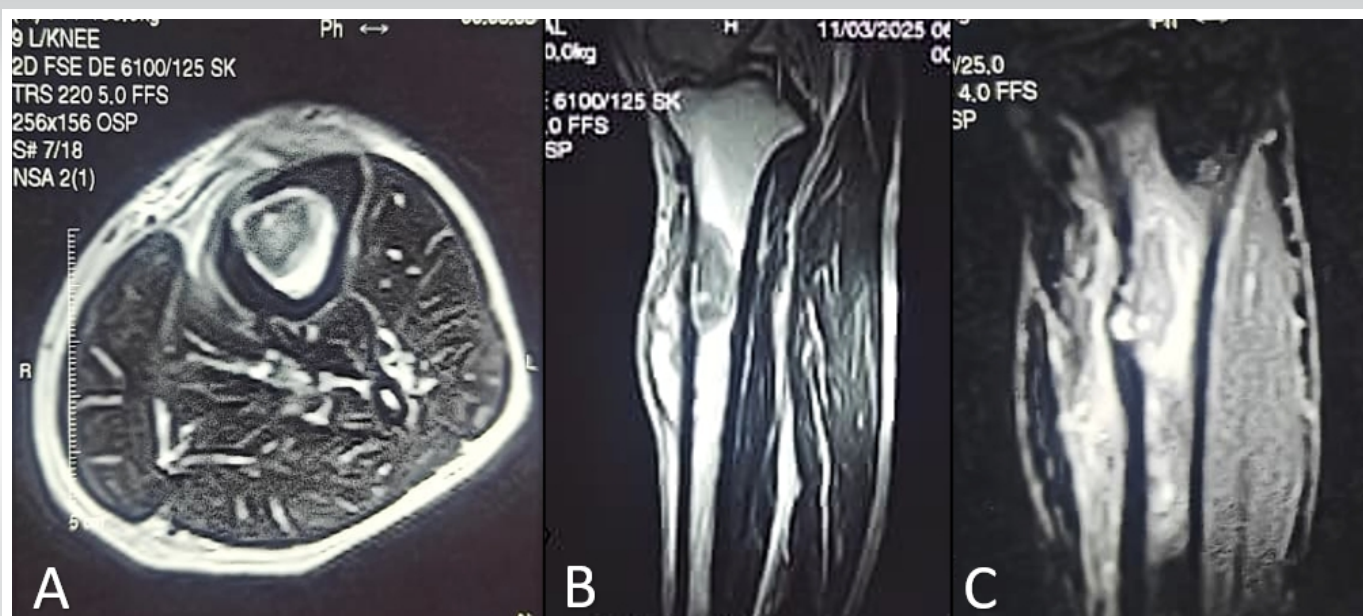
Preoperative magnetic resonance imaging of the left tibia. (a) Axial T2-weighted image showing a hyperintense intramedullary abscess in the proximal tibia with surrounding marrow edema. (b) Coronal sequence demonstrating cortical thinning and an anteromedial cortical breach. (c) Sagittal sequence revealing longitudinal intramedullary extension with associated soft-tissue inflammatory changes. The overall appearance initially suggested subacute osteomyelitis or Brodie's abscess.
